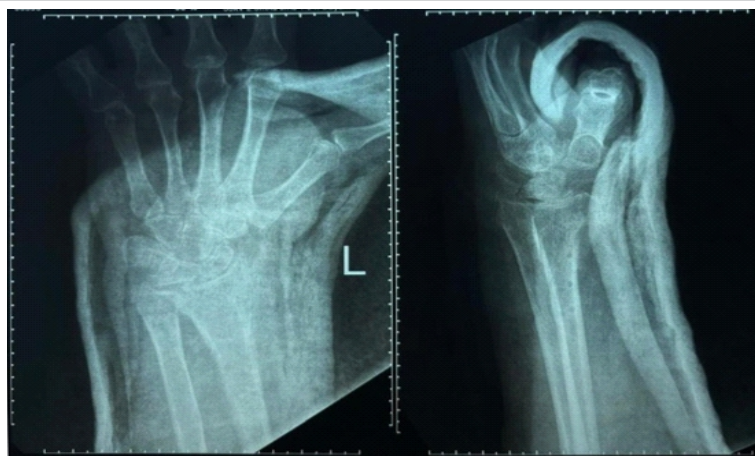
Post-operative radiograph showing implant removal with limb immobilized in a thumb spica splint.
